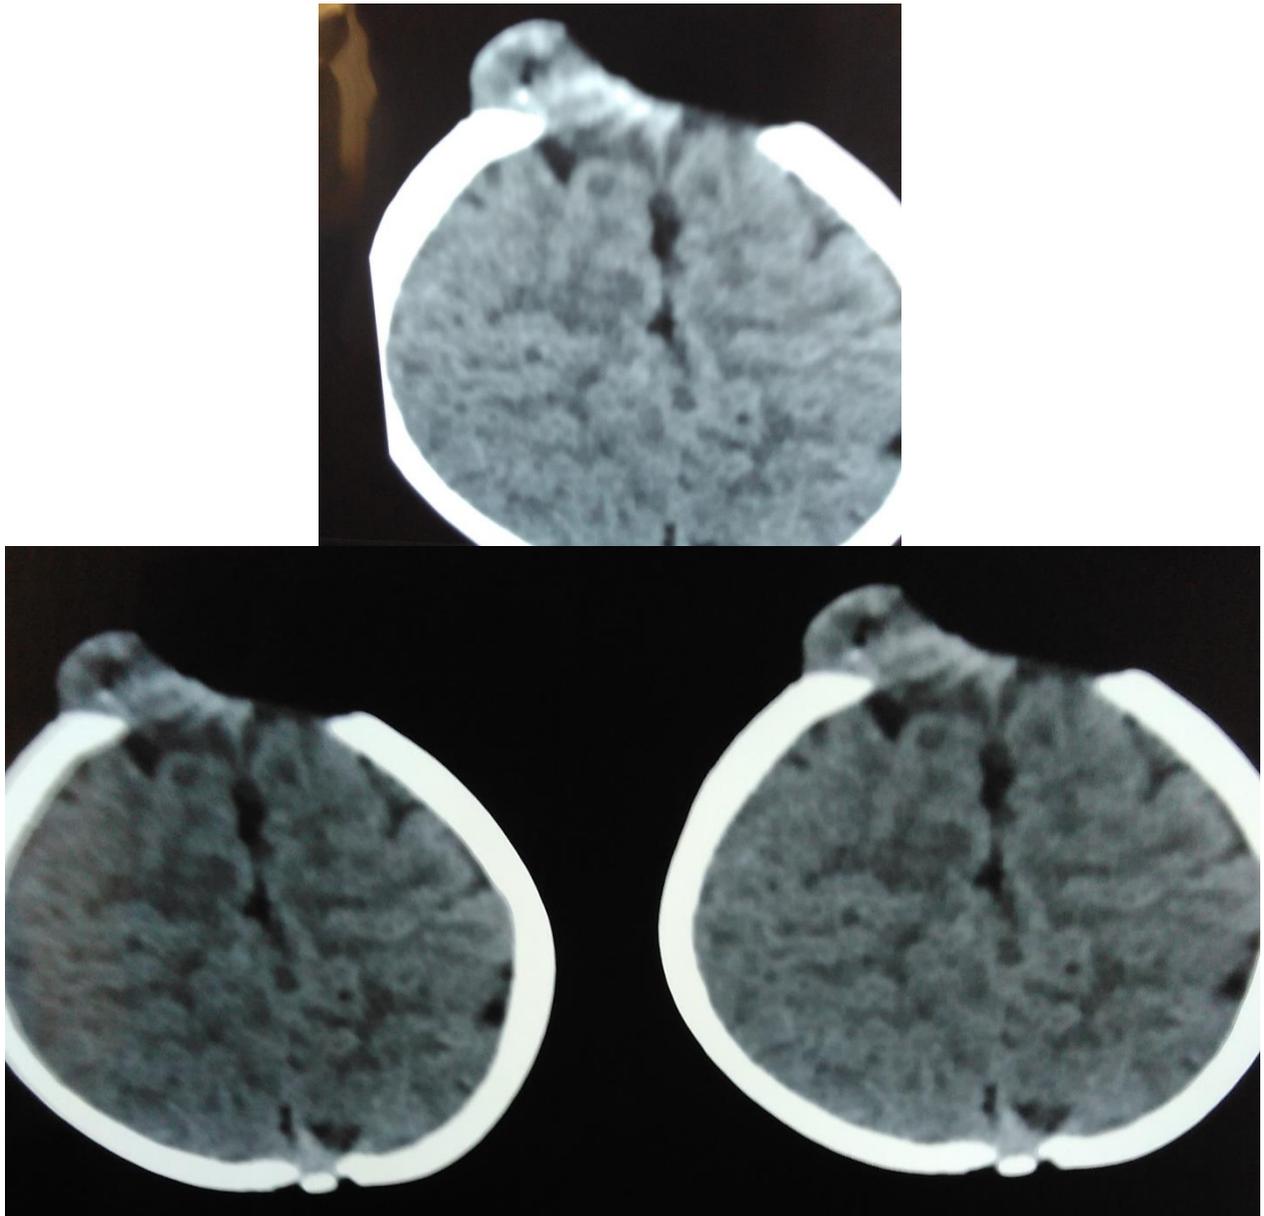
Case 4, CT scan of 11 month old child revealed a soft tissue density over the bone defect at sagittal sinus that enhanced after contrast administration
